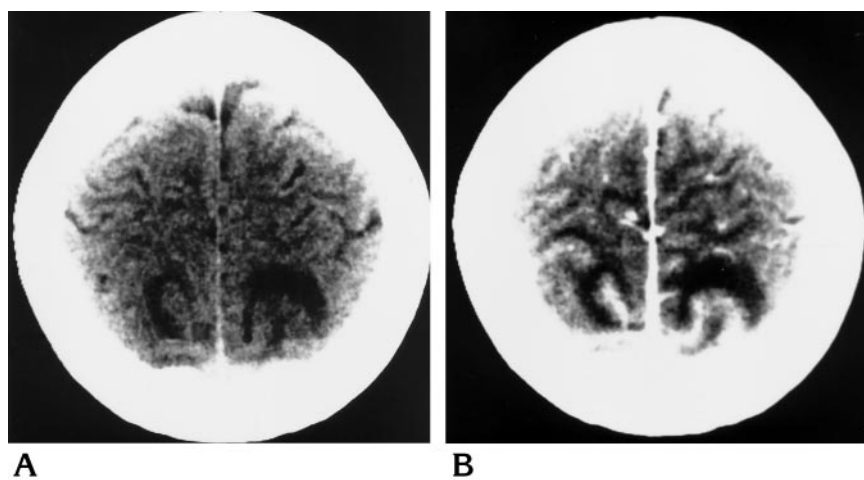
Case 4: 11-year-old girl with hypertension caused by a pelvic primitive neuroectodermal tumor. Axial CT scans before (A) and after (B) contrast administration show abnormal cortical enhancement and surrounding low attenuation.
